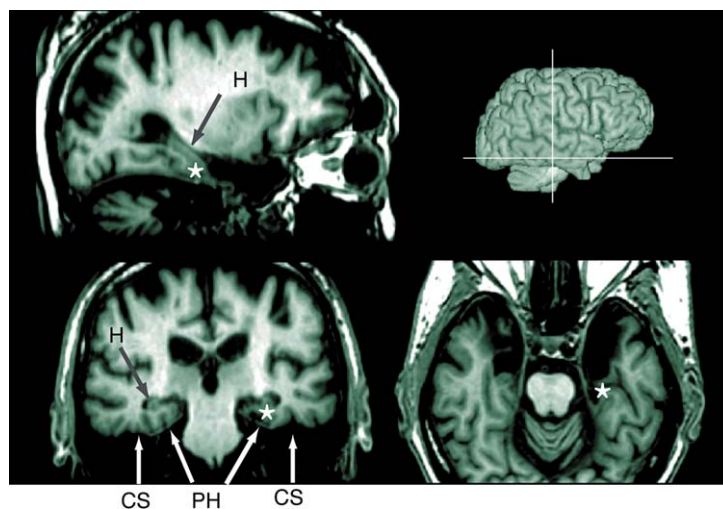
Multiplanar views of 18 averaged T1-weighted magnetic resonance imaging volumes showing preserved structures in H. M.'s left medial temporal lobe (MTL). The asterisk marks the intersection of the three viewing planes, just caudal to the left MTL resection, seen best in the transaxial view. Top left, sagittal view; bottom left, coronal view; bottom right, transaxial view; top right, surface rendering showing locations of transaxial and coronal planes. Abbreviations: CS, collateral sulcus; H, hippocampus; PH, parahippocampal gyrus. Reprinted from Corkin S (2002) What's new with the amnesic patient H. M.? *Nat. Rev. Neurosci.* 3(2):153–160, with permission from Macmillan Magazines Ltd.
